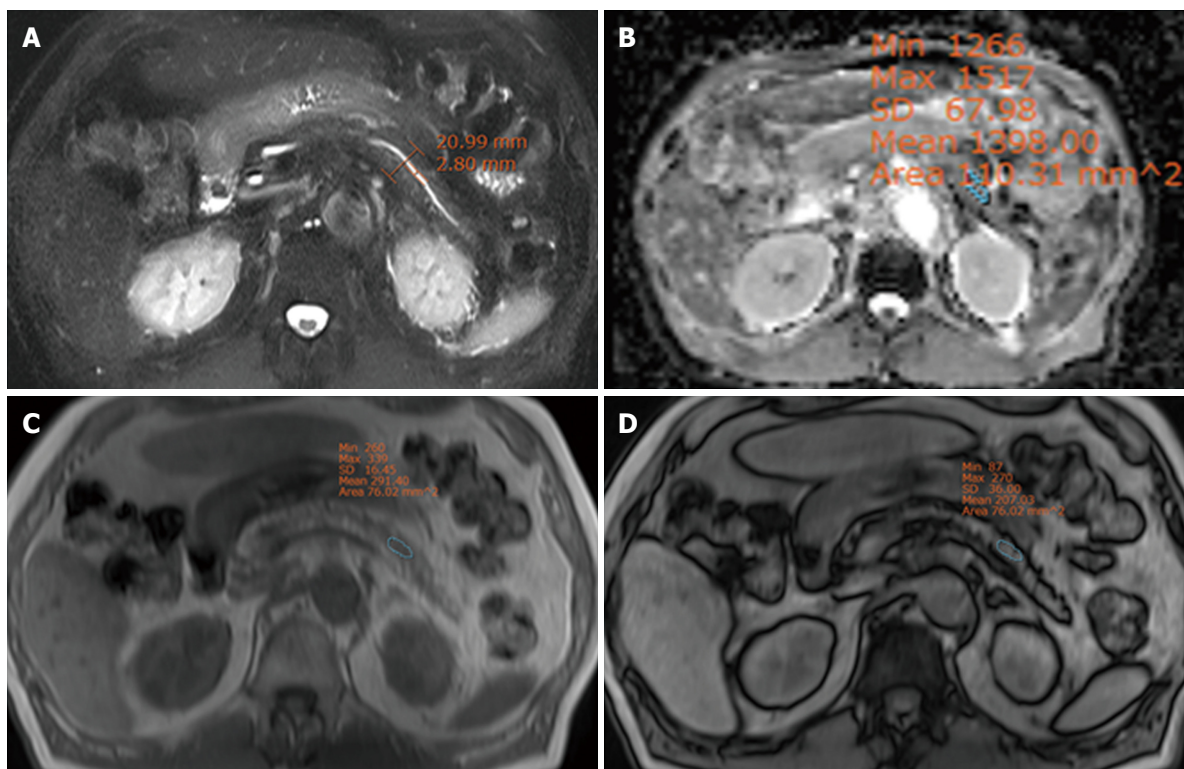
Pancreas cancer with a soft pancreas. Magnetic resonance imaging of a 74-year-old male with pancreas head cancer who was found to have a soft pancreas (durometer measurement: 8 DU). The diameters of the pancreatic duct and parenchyma were 3 mm and 21 mm, respectively (A). The apparent diffusion coefficient value of the pancreatic parenchyma was 1.398 mm²/s (B). The signal intensity of the pancreas on in-phase imaging was 291.40 (C) and on opposed-phase imaging was 207.03 (D).
